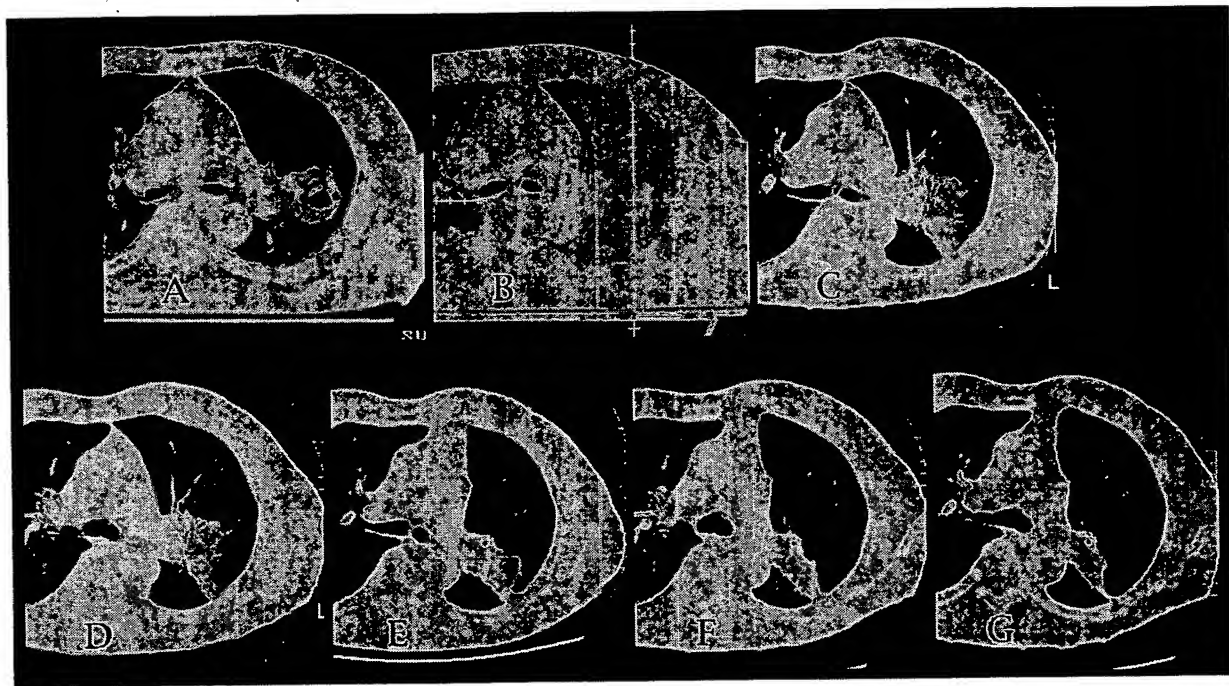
T2N0M0 squamous cell carcinoma of the lung. (A) A 4.5-cm tumor with the cavity seen on the positioning CT. To reduce the risk of marginal recurrence, conventional RT of 50 Gy in 25 fractions during 5 weeks was initially given. (B) After RT, shrunken tumor (<3 cm) and radiation-induced interstitial changes were seen. SRT of 40 Gy in 8 fractions during 2 weeks was given at the 80% isodose line of 3.5 cm in diameter. (C) Three months after SRT, the tumor was not clear but localized radiation-induced fibrotic changes were apparent. (D) Six months after SRT, the volume of the radiation fibrosis was reduced. (E) Nine months after SRT, the volume of the radiation fibrosis had reduced further but localized atelectasis was seen. (F) Twenty-five months after SRT, the atelectasis was localized. (G) Fifty-five months after SRT, the volume of the atelectasis was somewhat smaller.
